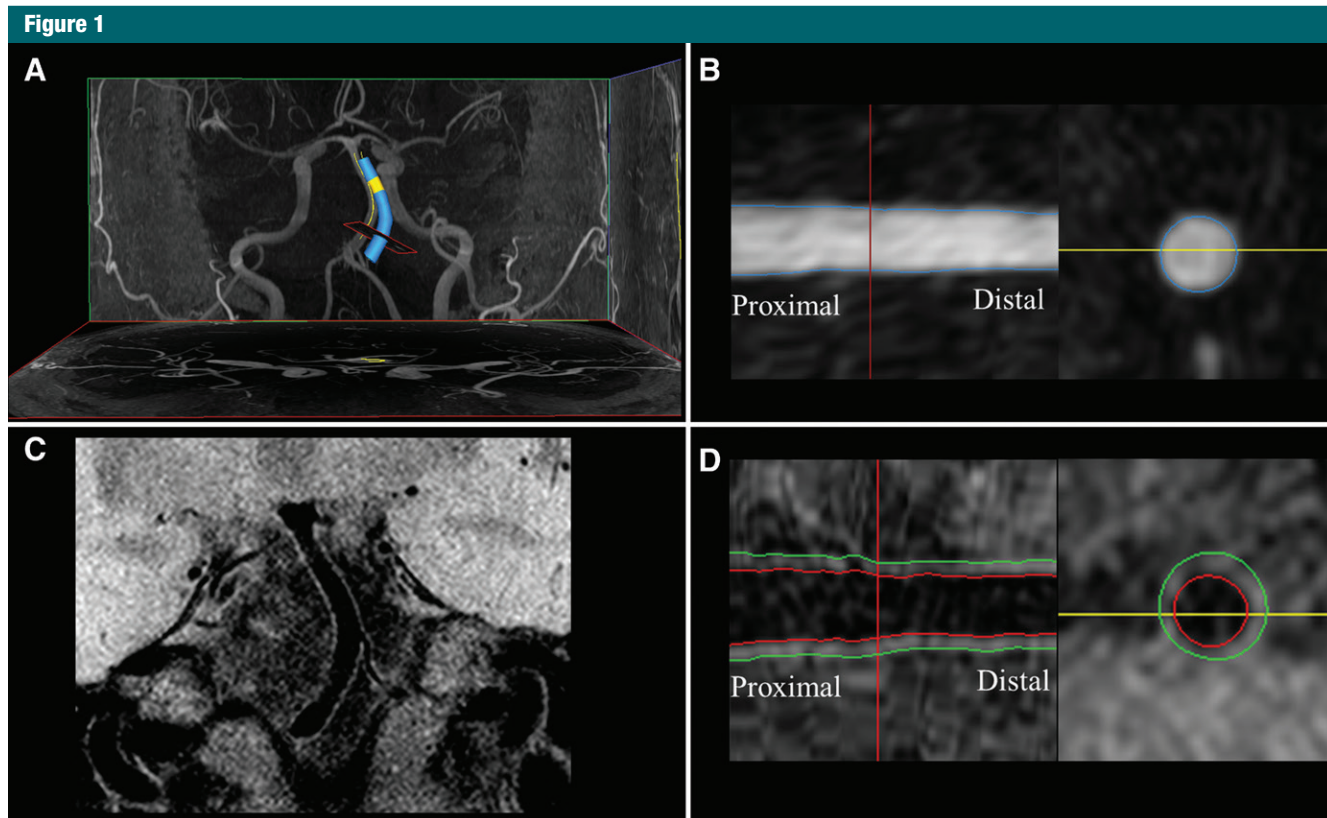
MR images of intracranial arteries in 79-year-old white man. *A*, Basilar artery lumen is contoured on MR angiogram with 3D nonuniform rational B-splines (or NURBS) modeling (LAVA software). *B*, Two-dimensional (2D) long-axis view shows that the contoured lumen is unfolded (left). *C*, *D*, Basilar artery segment identified on *C*, black-blood MR image is coregistered with MR angiogram lumen data and the wall contoured and unfolded in *D*, 2D long-axis view (left). Cross-sectional images are reconstructed to facilitate manually adjusting contours (*B* and *D*, right, corresponding to position of red line).
